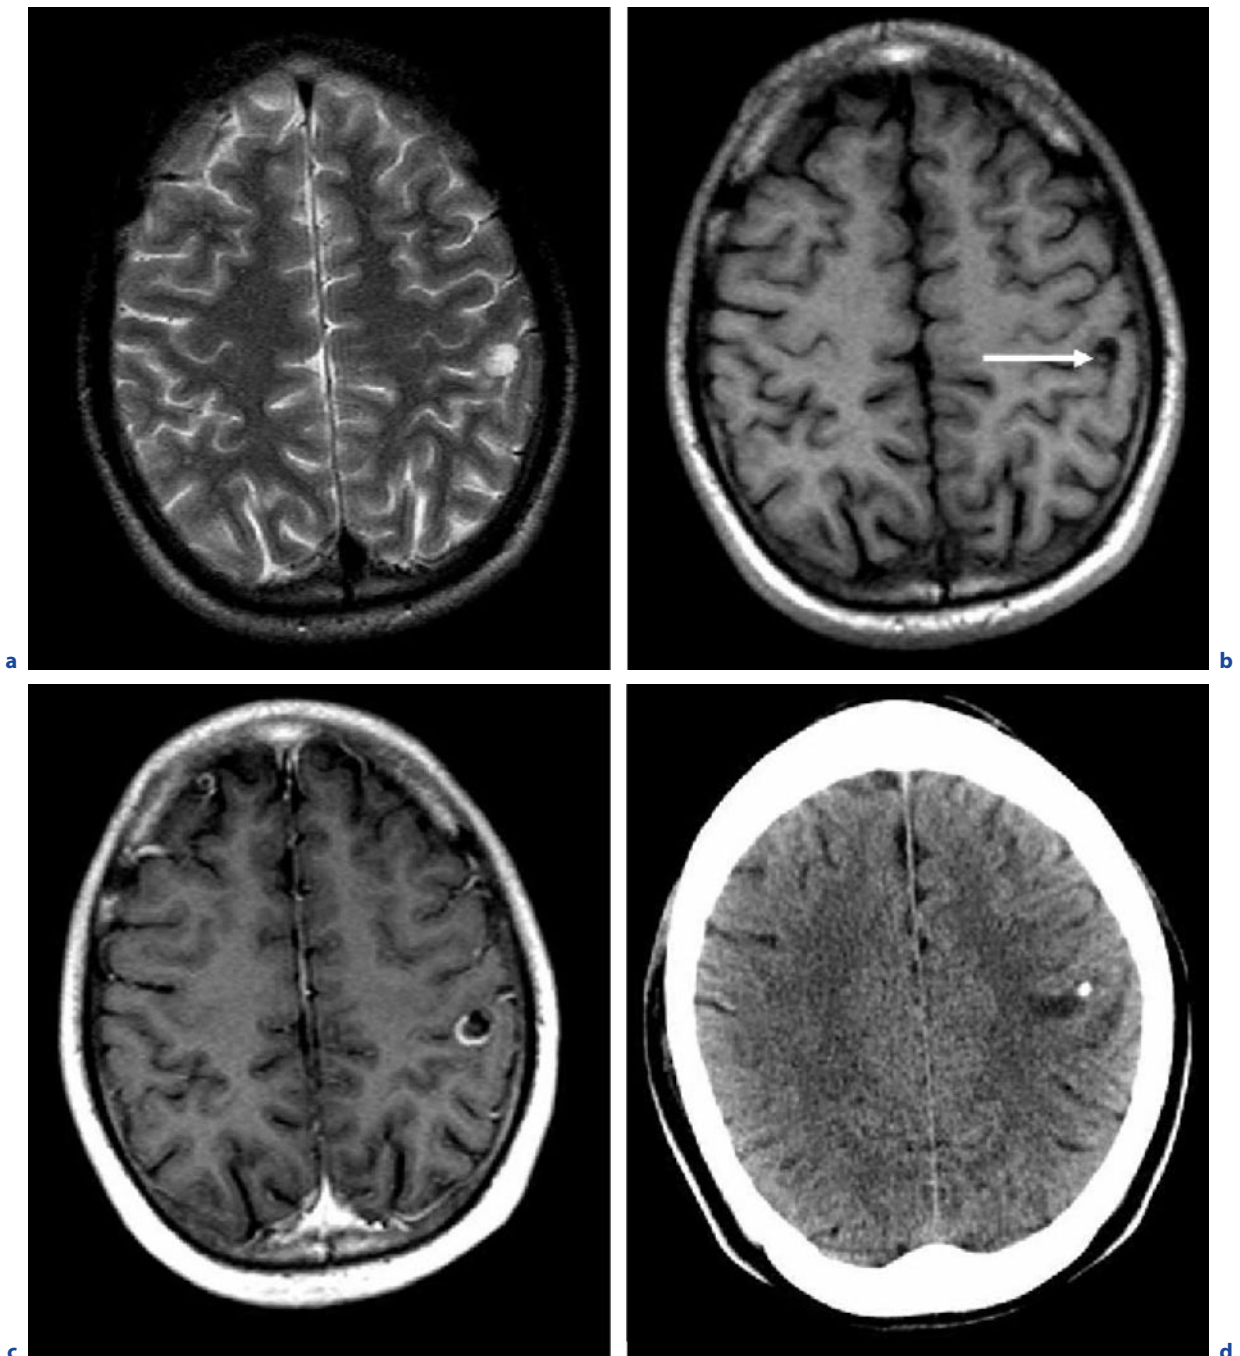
Neurocysticercosis in a 22-year-old man. a Axial T2-weighted image. b Axial T1-weighted image before contrast administration. c Axial T1-weighted image after contrast administration. d Axial CT. e,f see next page
